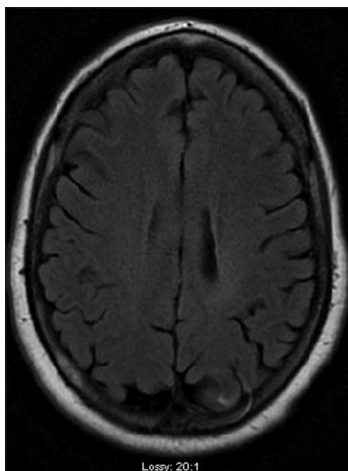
T2 FLAIR MRI one year postoperative
